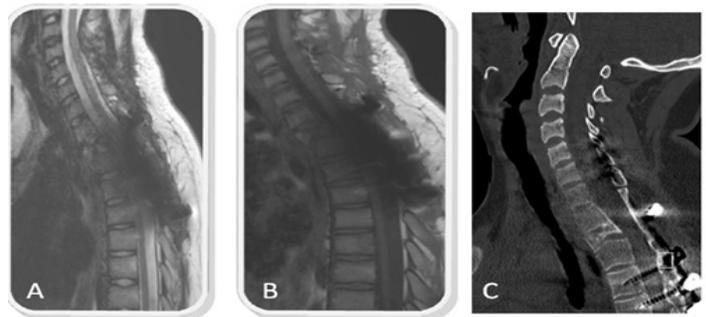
Post-operative radiographic findings (A) sagittal T2-weighted MRI, (B) sagittal T1-weighted MRI, and (C) sagittal spinal CT (bone window).
